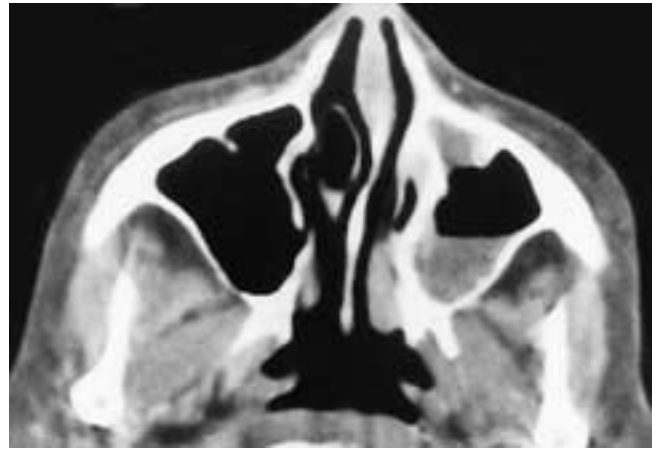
Axial CT scan shows a left maxillary sinus mucoid attenuation air-fluid level with minimal mucosal thickening. The right maxillary sinus is normal. Clinically this patient had acute bacterial sinusitis.
